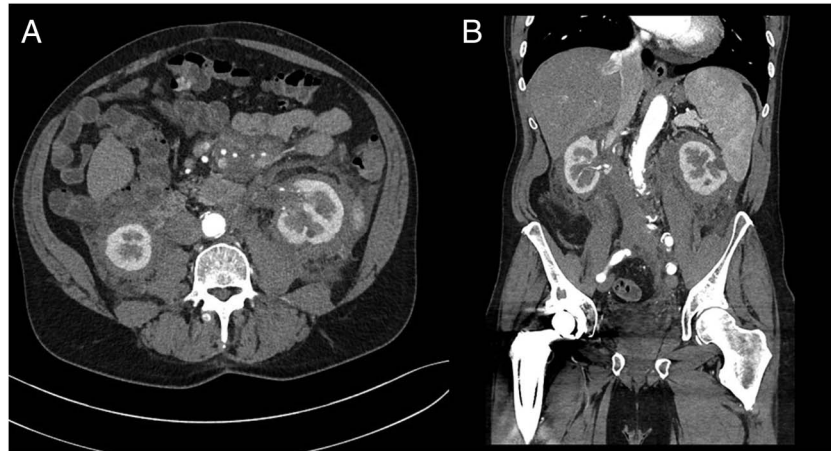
(A) Axial section of the abdominal and pelvic CT demonstrating bilateral kidney involvement and a normal pancreas. (B) Coronal section of the abdominal and pelvic CT demonstrating bilateral kidney involvement. CT, computed tomography.
